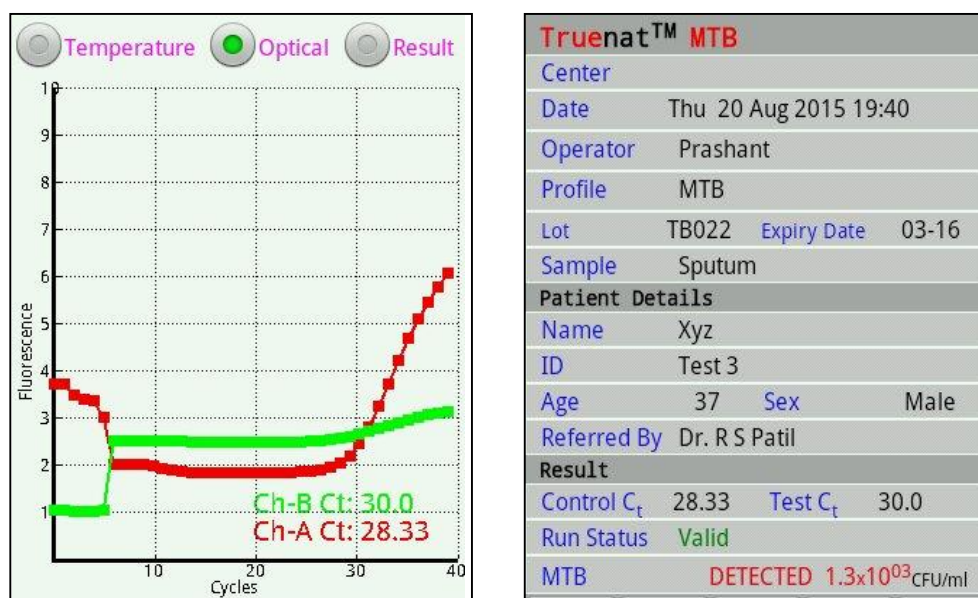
CT value and melting curve of positive MTB result
